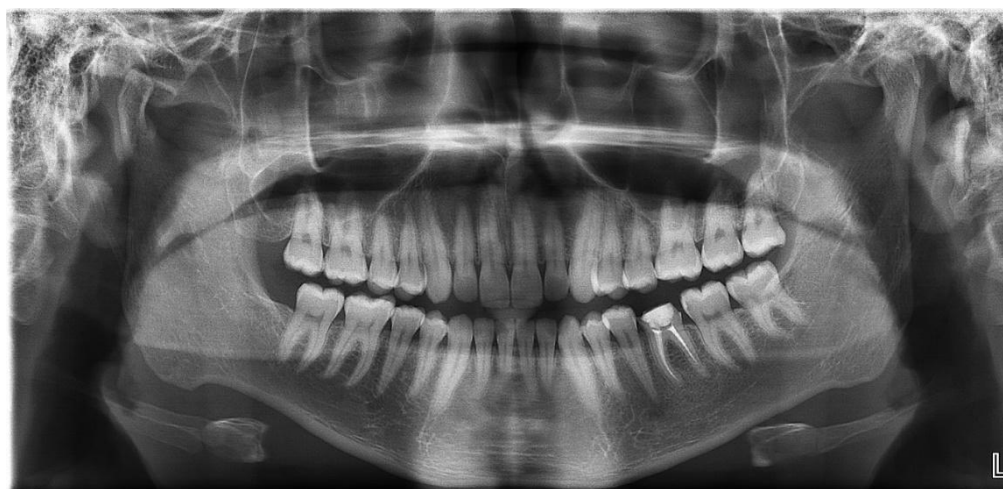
Panoramic radiograph showing styloid procesus type II
